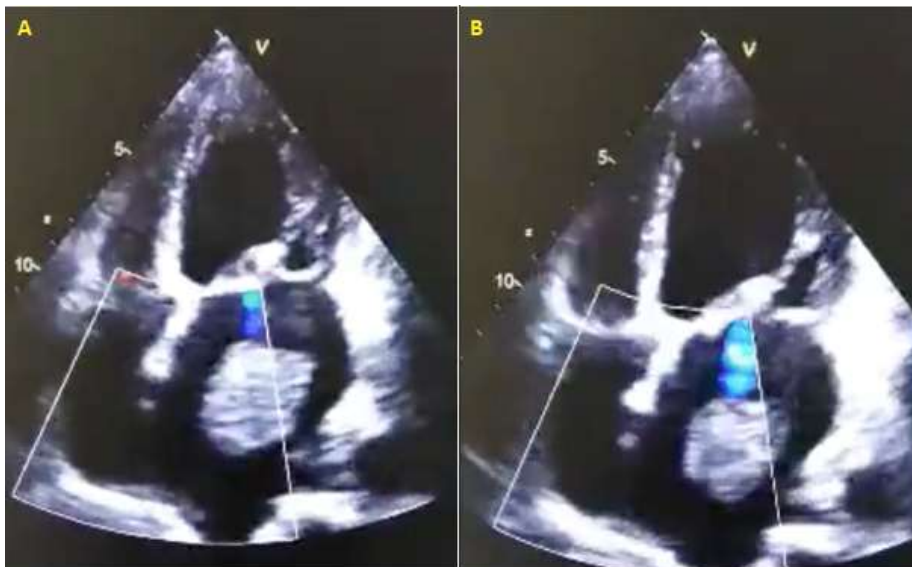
(A,B) transthoracic echocardiography showing a large round mass free-floating in a dilated left atrium with no attachments to the interatrial septum, associated to a mild mitral regurgitation
